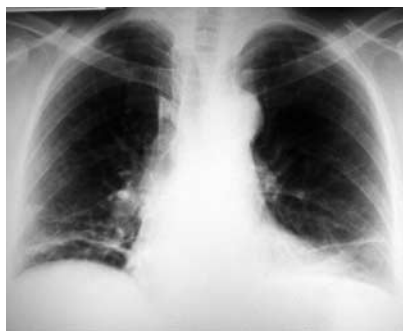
Simple chest radiograph.
